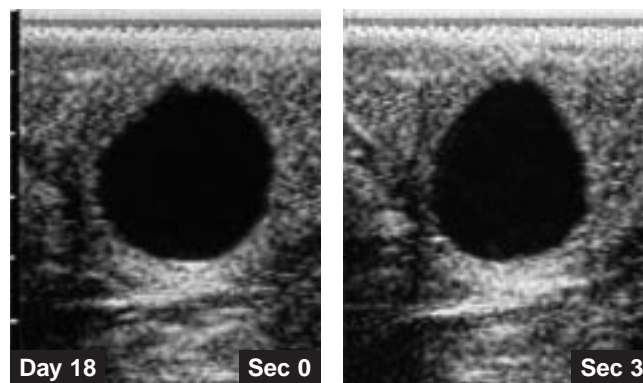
Example of uterine massage of the vesicle on Day 18. The vesicle changed shape when viewed continuously. The two sonograms were taken at an interval of 3 seconds.
